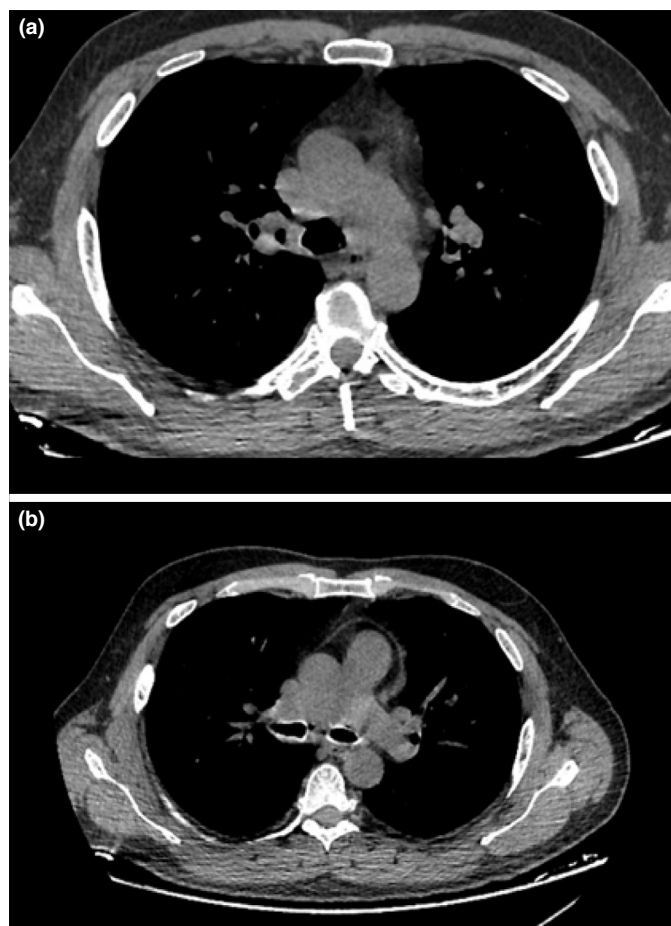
Follow-up CTA reveals a regression of the mass and lymphadenopathies (LAPs), along with the disappearance of carina compression. (a) Trachea level (b) carina level
